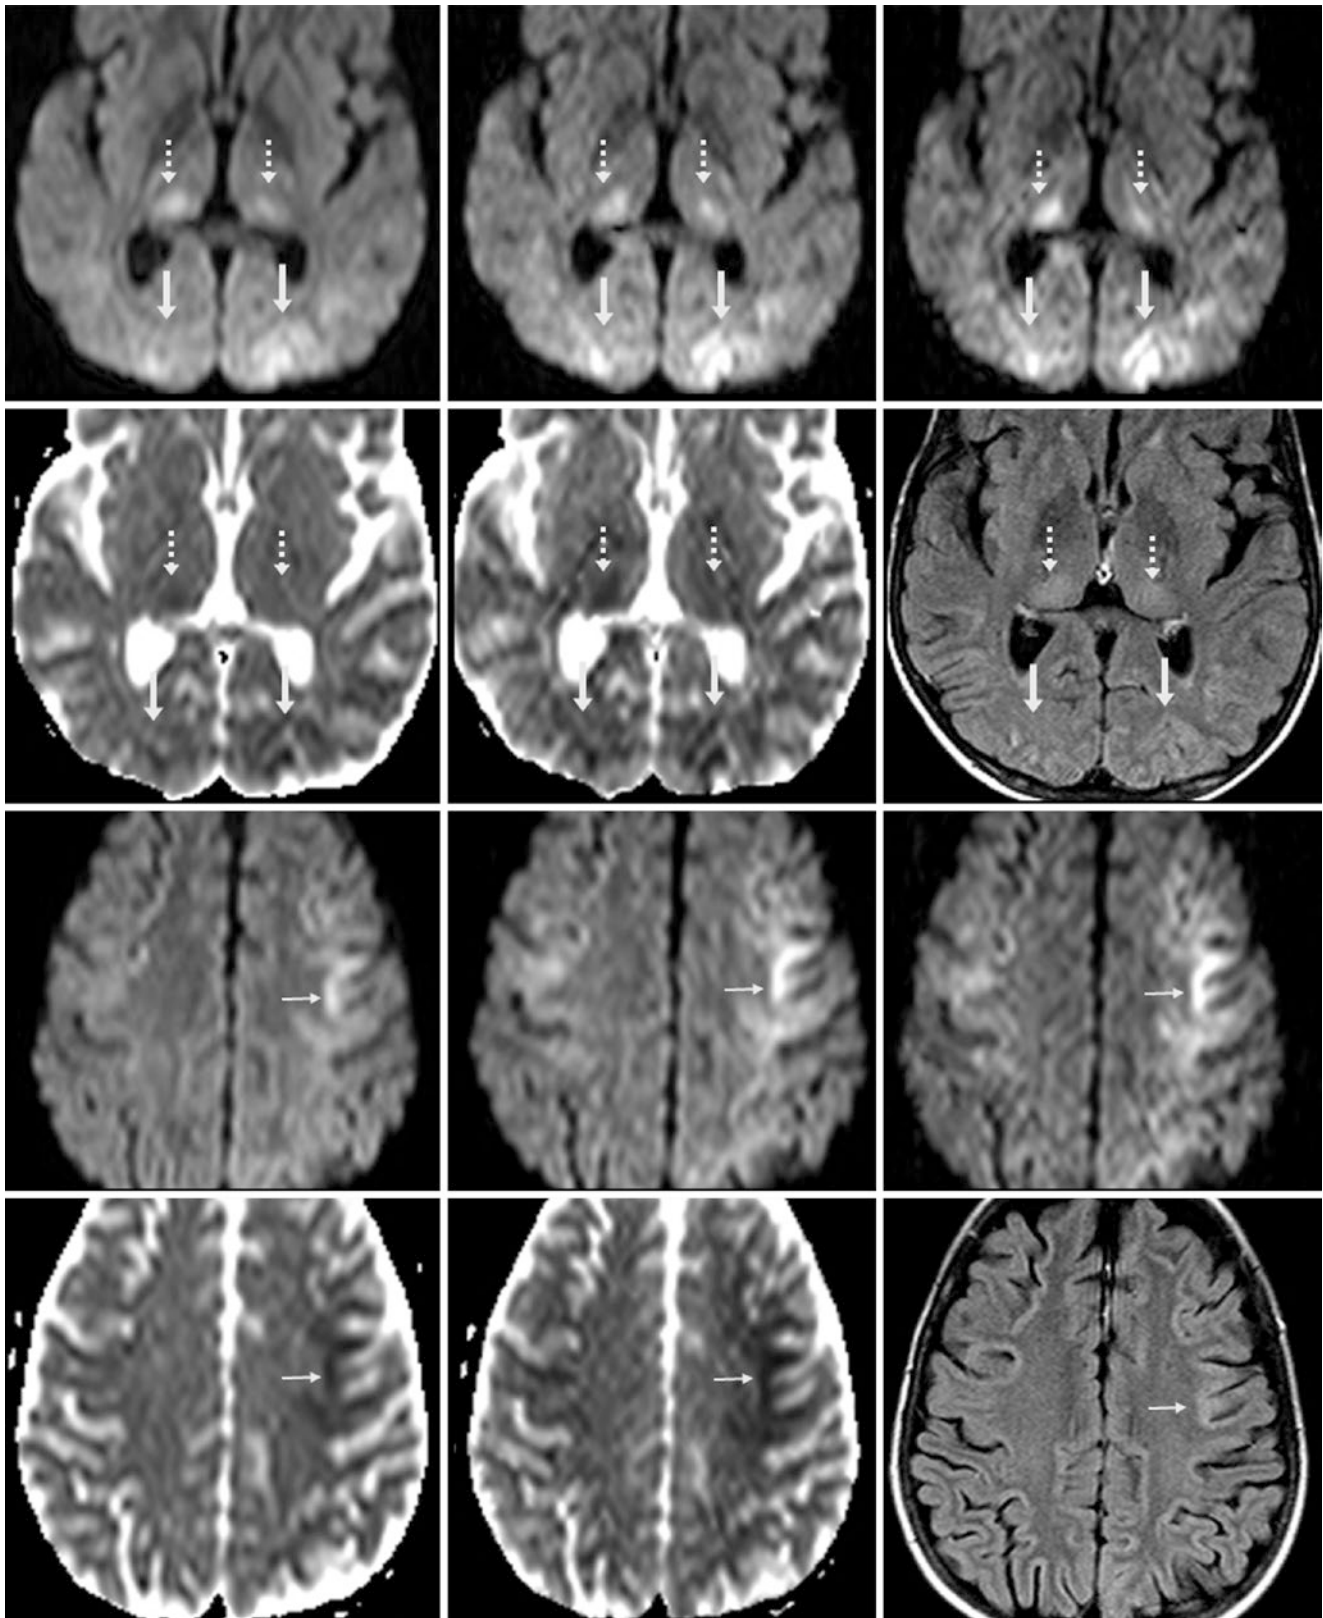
Comparison case of hypoxic ischemic encephalopathy (HIE) in a 4-year-old who suffered cardiac arrest after trauma. *Top row:* A 1.5 T MRI with DWI shows increasingly visible cortical (arrows) and thalamic (dashed arrows) findings of HIE at $b=1000$ (left), 1500 (middle), and 2000 (right) s/mm^2 . *Second row:* The ADC maps appear almost normal at $b=1000$ s/mm^2 (left) but seem more abnormal at $b=2000$ s/mm^2 (middle). FLAIR (right) also appears nearly normal. *Third row:* At
